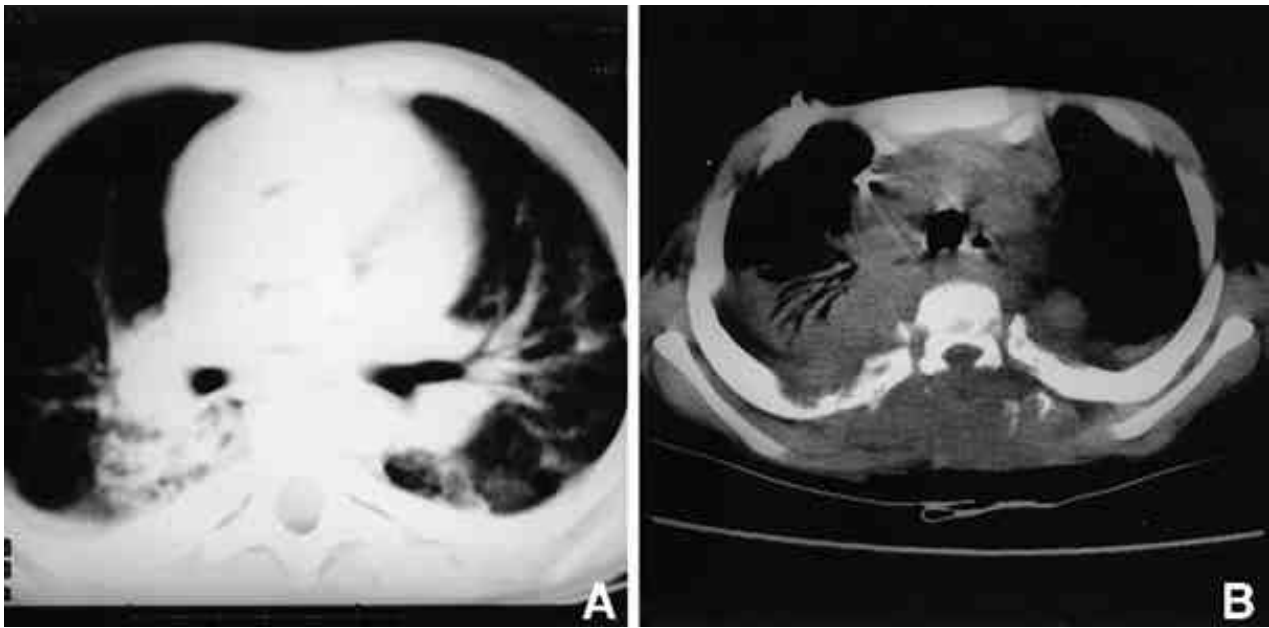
A : Chest CT scan with lung settings shows patchy and confluent consolidations in both lungs. B : Chest CT scan 7 months later shows a mass-like lesion in left and consolidation in right upper lobe with destruction of adjacent ribs. Note laminectomy state of the spine.
